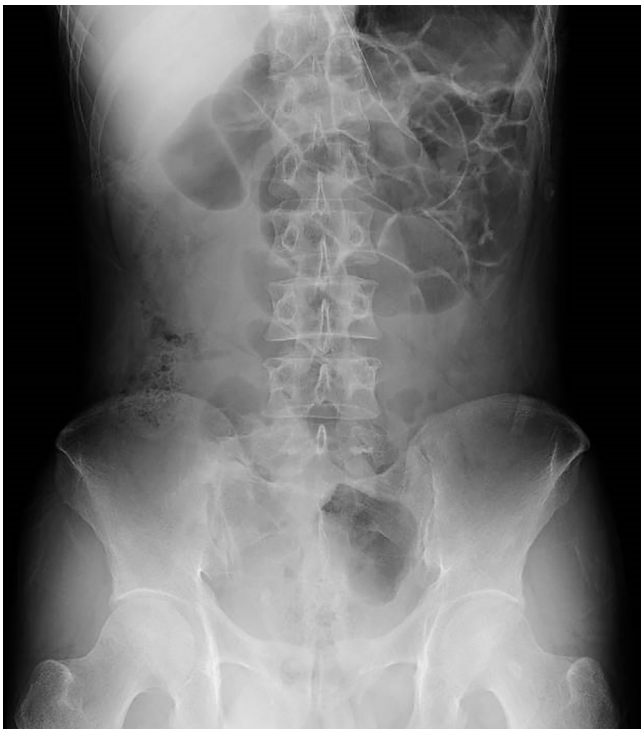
A plain x-ray imaging of the abdomen showed bowel gas in his left upper abdomen.
